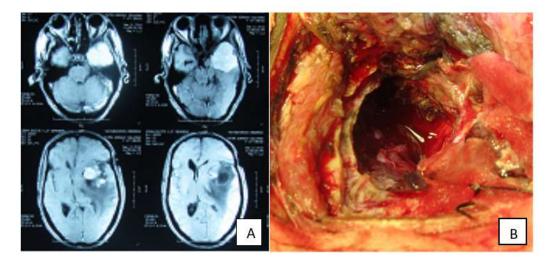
Image (A) preoperative MRI showing left temporal tumor in T1 axial cut with some sorrowing edema, Image (B) is operative view after total resection of the tumor
